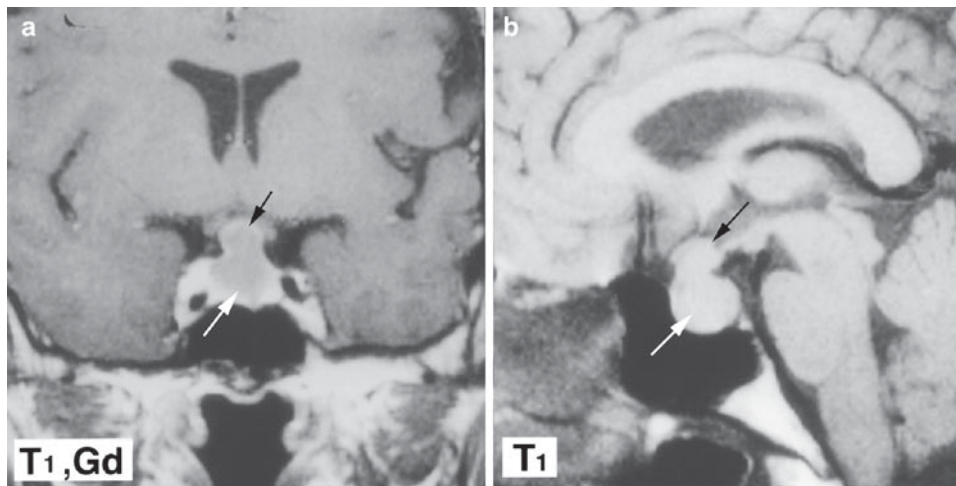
MRI of Rathke's cleft cysts (arrows). (a) Coronal T1-weighted MRI scan after gadolinium enhancement. (b) Sagittal T1-weighted MRI scan. The cyst is located in the suprasellar (shown by black arrows) and intrasellar (shown by white arrows) regions
